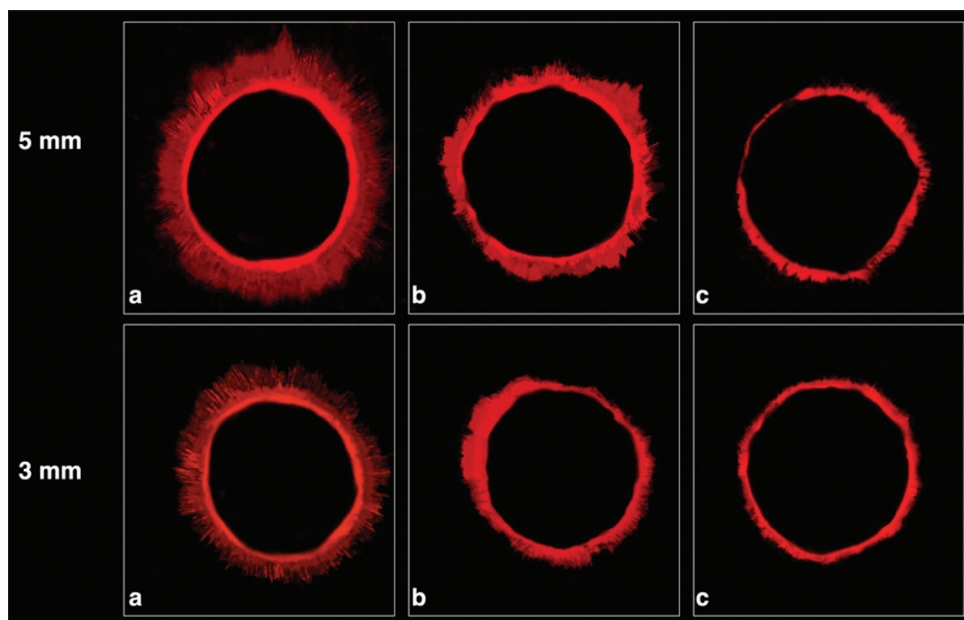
Representative images of dentinal tubular penetration of biosealer in groups. (a) Ultrasonic activation, (b) sonic activation, and (c) single-cone technique at the 3 and 5 mm levels
